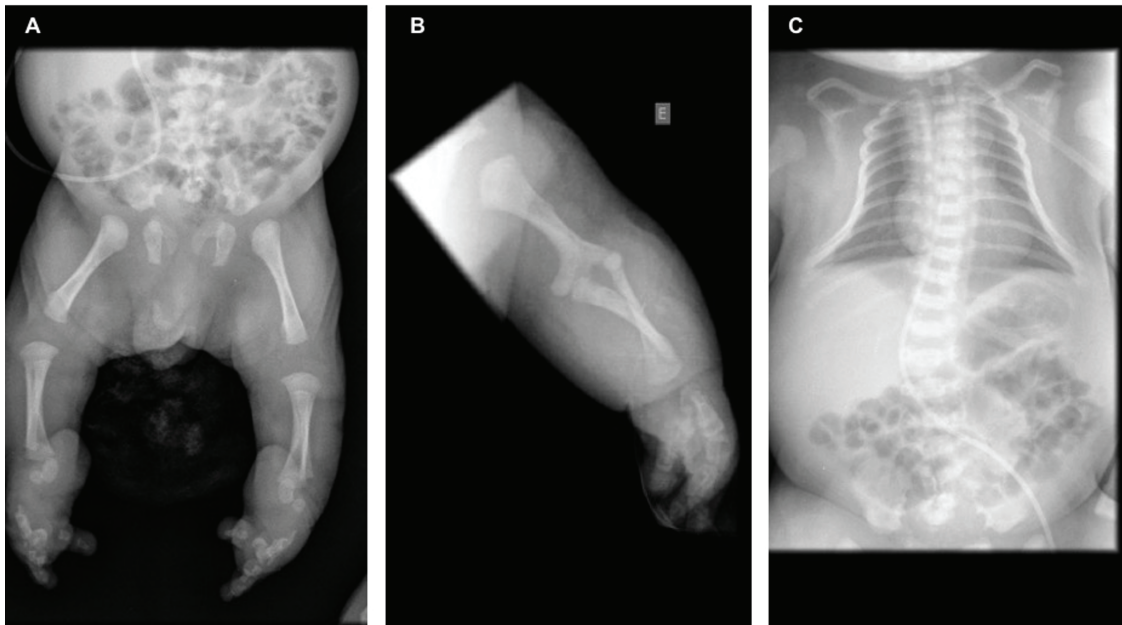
X-ray images of the newborn showing micromelia of lower (A) and upper (B) limbs and thoracic narrowing (C)
